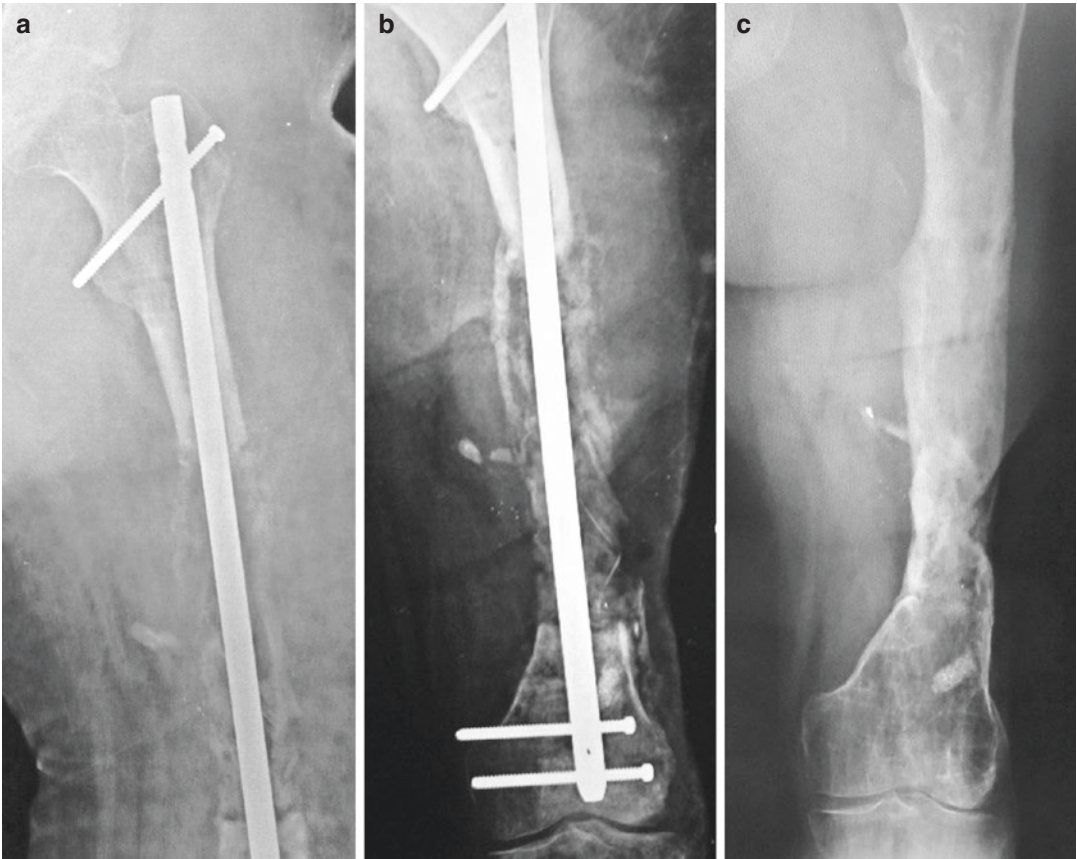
(a) Post-op X-ray of locked femoral nail and bone graft. (b) X-ray 4 months later showing progressive maturation of the graft; (c) femur healed 19 months after
